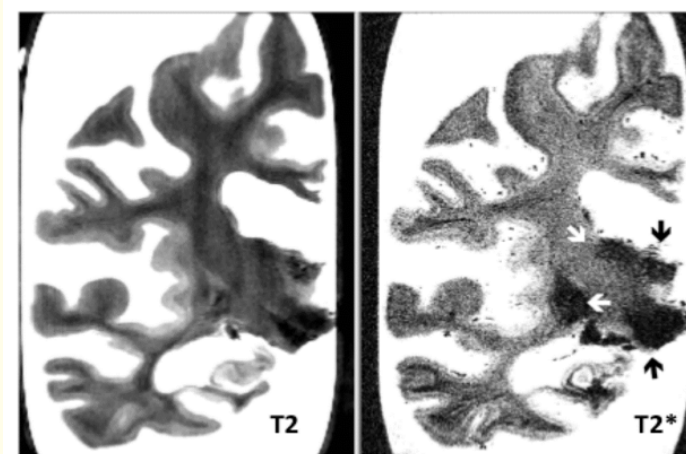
7.0-tesla MRI of a post-mortem section of a brain hemisphere with frontotemporal lobar degeneration. There is extensive frontal and temporal atrophy on T2 and T2*. Iron accumulation in the basal ganglia (white arrows) and in the thalamus and subthalamic nuclei (black arrows) is seen on the T2* sequence (INSERM 1171, France).
